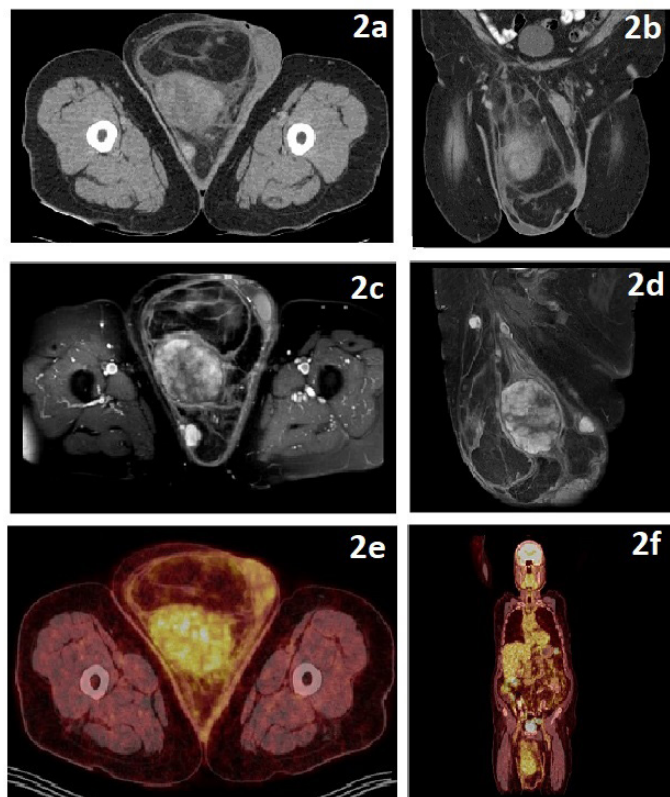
2ab: Axial and coronal CT images; 2cd: Axial and sagittal MRI images; 2ef: Axial and coronal PET scan images
